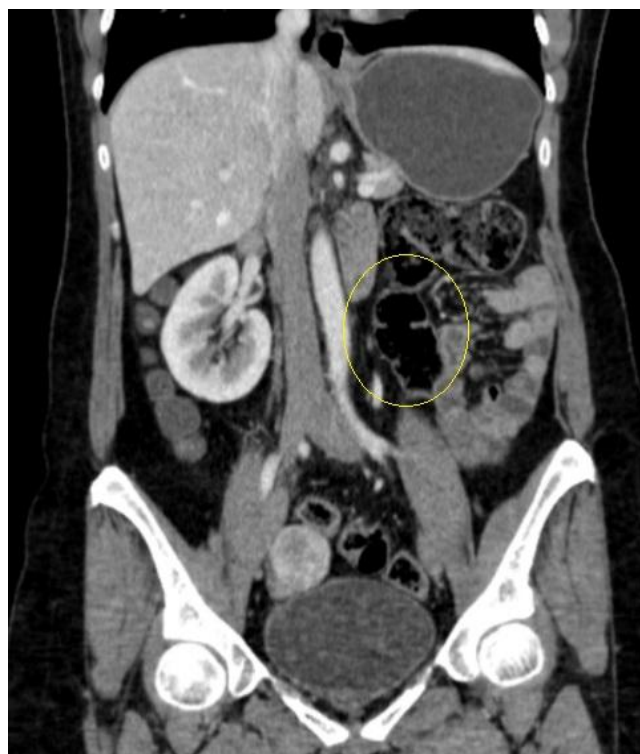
Absence of left kidney on abdominal CT
